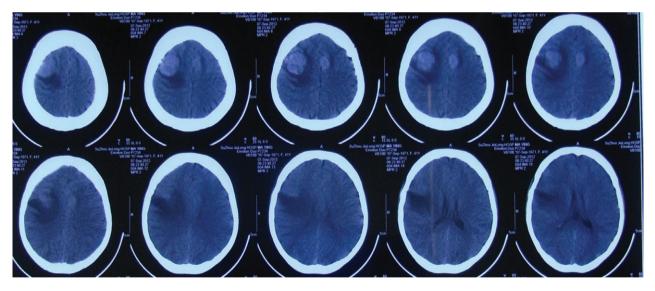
Brain computed tomography scan before treatment.
